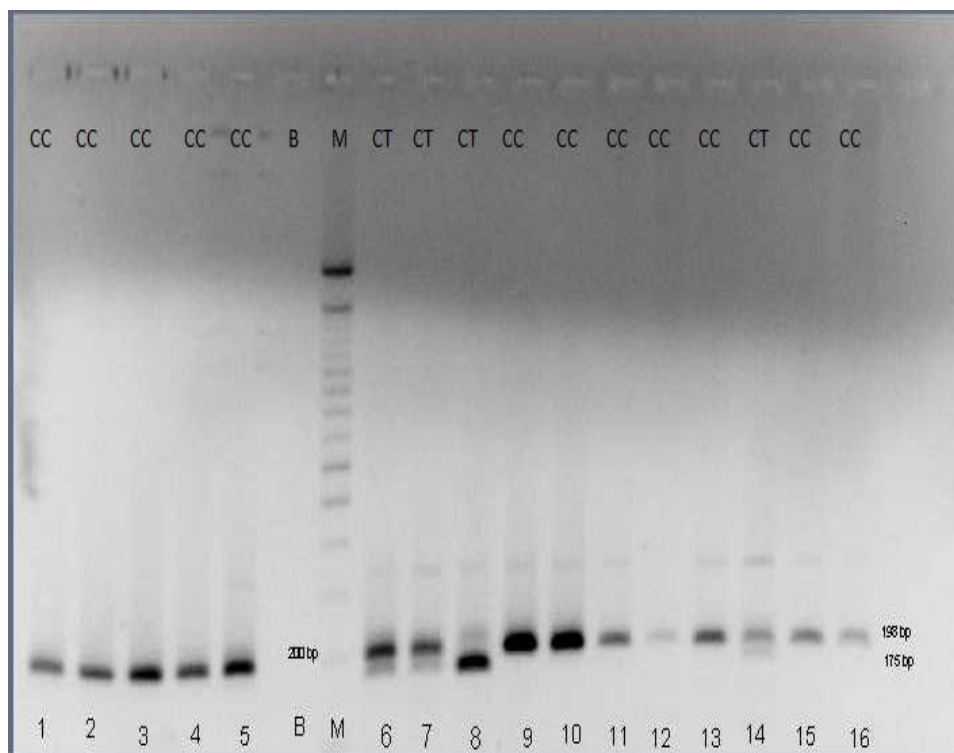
Agarose gel of MTHFR C677T polymorphism PCR-RFLP product, row 1-5; 8-18: digestion result (CC: 198 bp; CT: 198 bp, 175 bp; TT: 175 bp), B: Blank, M: Marker
